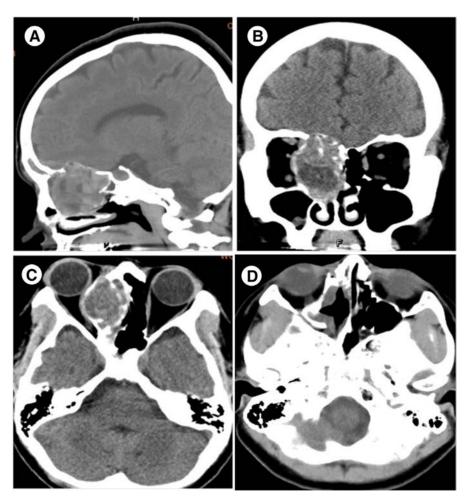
Preoperative contrast-negative computed tomography demonstrated a heterogeneous solid lesion involving the right ethmoid sinus, maxillary sinus, orbit, and skull base. Mixed densities and bone remodeling were noted: sagittal (A), coronal (B), and axial (C). Postoperative contrast-negative computed tomography demonstrated mucosal thickening of the right frontal, maxillary, ethmoid, and sphenoid sinuses (D).
